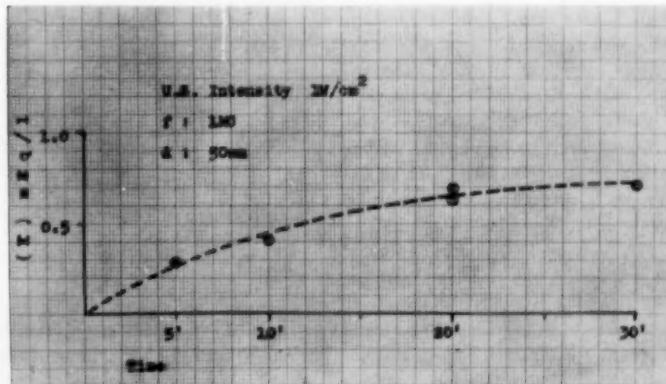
Relationship of potassium diffusion to length of exposure to ultrasound.
